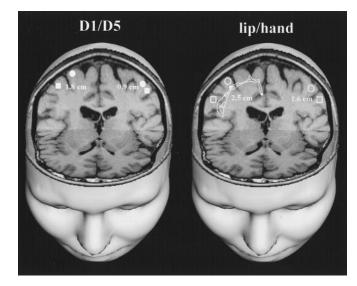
Left: Projection of the equivalent current dipole (ECD) localizations for D1 (filled square) and D5 (filled circle) onto individual MRI slices for one representative patient. Note the reduction in the cortical extension of the hand from 1.8 cm (unaffected side) to 0.9 cm (complex regional pain syndrome [CRPS] side). Right: Projection of the ECD for the center of the hand (open circle) and the lower lip (open square) onto individual MRI slices. Note the inferior and lateral shift of the hand position toward the lip on the CRPS side (distances between lip and hand 2.5 cm for the normal and 1.6 cm for the CRPS side).
